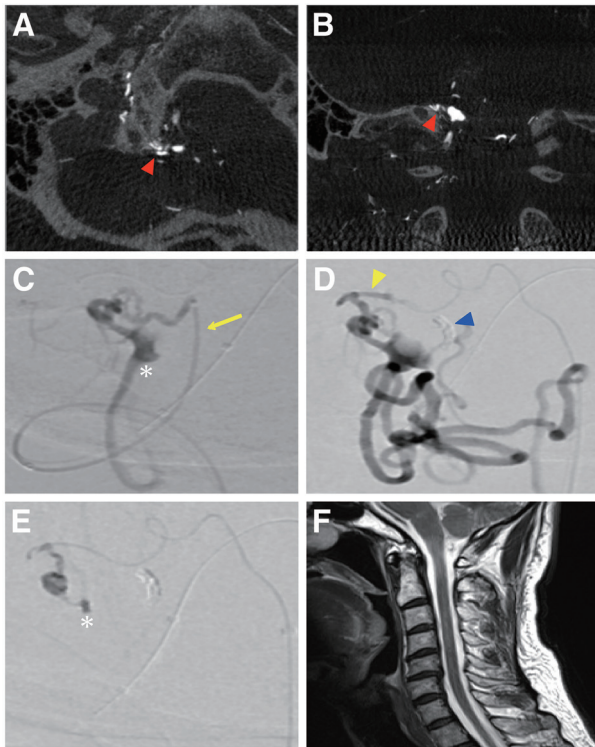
Axial (A) and coronal (B) 3DRA source images of a right AphA demonstrating that the fistula point (red arrowhead) is located on the medial side of the right jugular tubercle. Superselective angiograms (C–E) are the same working angle views. (C) An Excelsior SL-10 microcatheter (Stryker, Kalamazoo, MI, USA) was navigated into a right VA feeder (yellow arrow). The asterisk indicates a venous pouch. A DeFrictor Nano Catheter was navigated into the distal portion of a jugular branch from the right AphA. (D) After the placement of coils (blue arrowhead indicates the digital-subtracted coil mass) in the VA feeder, superselective angiography from a DeFrictor Nano Catheter demonstrates that the retrograde depiction of a right VA main trunk is not confirmed (yellow arrowhead, AphA feeder). (E) 17% n-butyl-2-cyanoacrylate was injected from a DeFrictor Nano Catheter, and the glue slightly penetrated the venous pouch (asterisk) through the fistula. DSA from a right VA and a right common carotid artery show the disappearance of foramen magnum DAVF (not shown). The sagittal section of the postoperative MRI (F) shows that the T2-hyperintensity and swelling in the cervical spinal cord decreased. AphA, ascending pharyngeal artery; DAVF, dural arteriovenous fistula; VA, vertebral artery; 3DRA, three-dimensional rotational angiography
